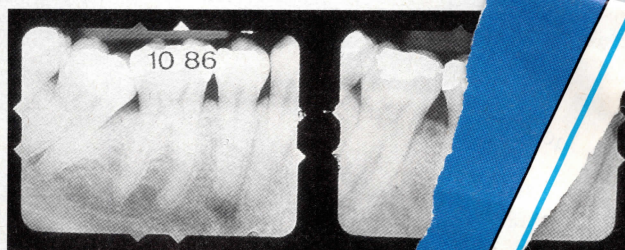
Pre- and postorthodontic radiographs of the mandibular right quadrant. The preoperative radiograph demonstrates molar tipping despite intact dentures. The postoperative radiograph shows the result of re-establishment of proper tooth position.
